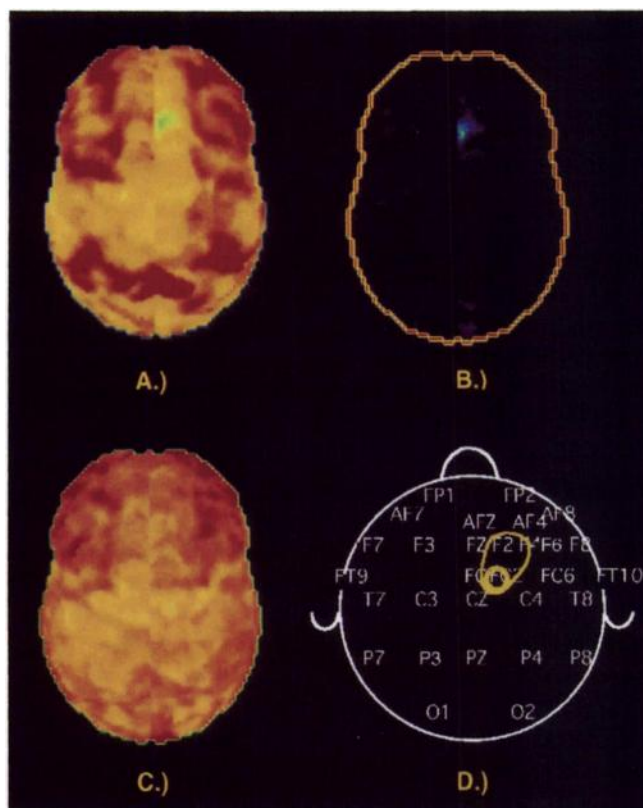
Case study. (A) Superior view on surface-projected ¹⁸F-FDG PET image. (B) Corresponding z score image. (C) Corresponding [¹¹C]FMZ image of 18-y-old woman. (D) Seizure onset during EEG.
